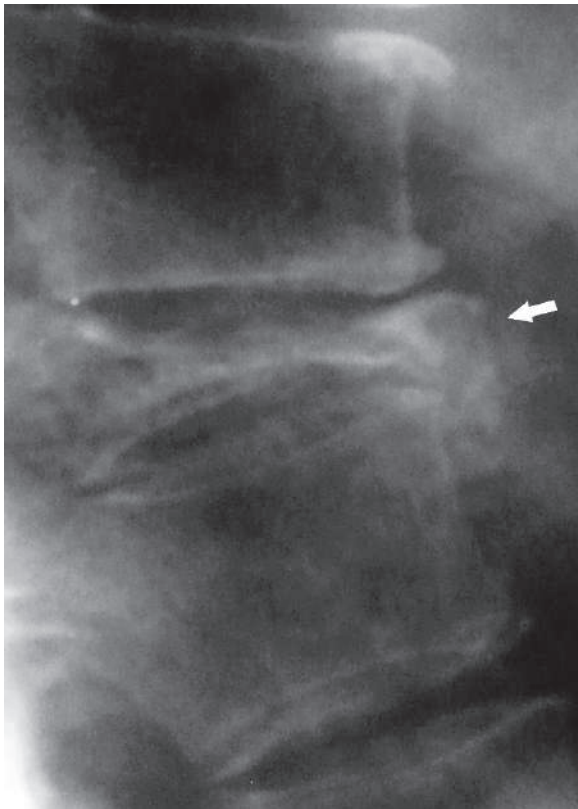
Lateral plain thoracic vertebral radiograph of a patient with multiple myeloma shows vertebra plana (*arrow*)
